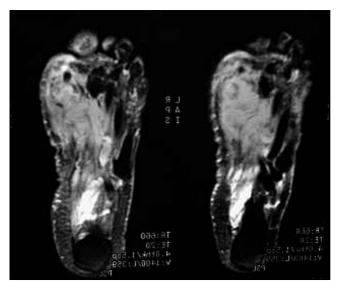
Foot MRI of patient.
